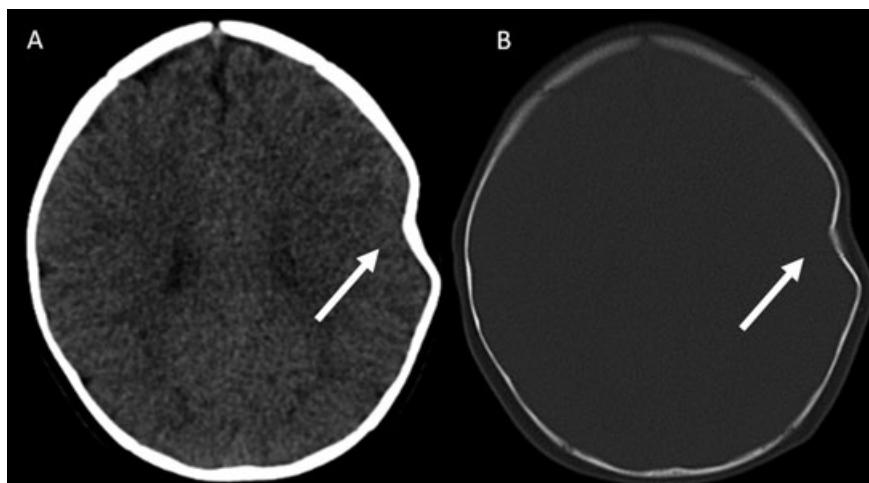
Axial CT images (A, B) of an 8-month-old female show a typical depressed “ping-pong” fracture (arrow). No underlying intraxial or extraxial brain lesion is noted.
